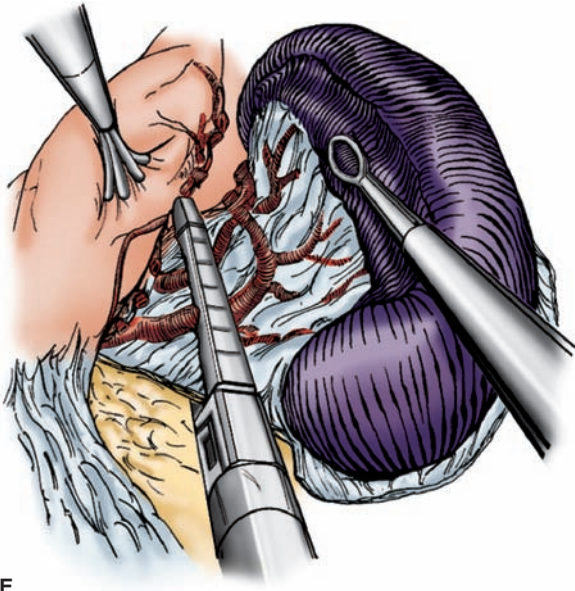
Steps of laparoscopic splenectomy. A. Mobilize the splenic flexure of the colon using ultrasonic dissecting shears to free the lower pole of the spleen. B. Free the lateral attachment of the spleen, leaving the superior attachments to the diaphragm intact for later division. This way premature medialization of the spleen is prevented. C. Divide the short gastric vessels using ultrasonic dissecting shears. D. Medial rotation of the stomach can help visualize the superior most vessels. Special care and attention should be given to these vessels that are often very short in length. E. Divide the splenic hilum using endoscopic staplers.
